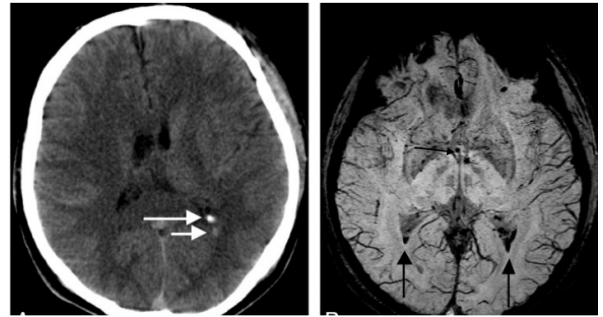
CT Scan showing IVH in occipital horn & MRI showing occipital IVH with periventricular blooming
